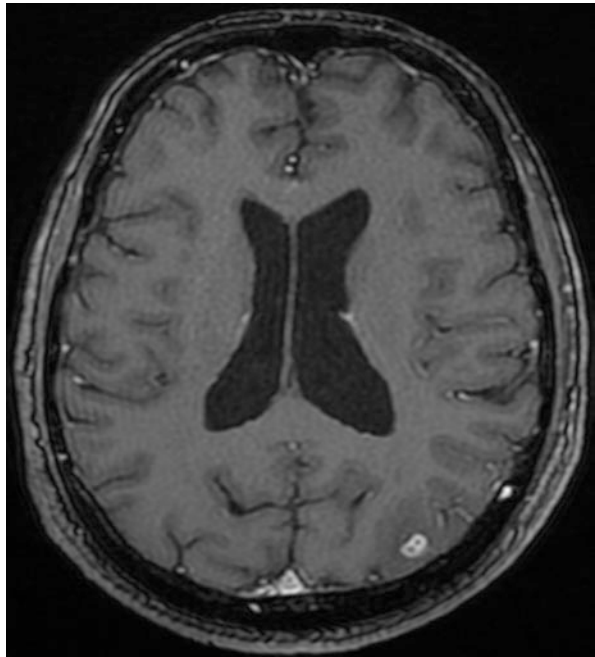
MR axial FLAIR and T2 images showing focal ring-like lesions consistent with brain abscesses or tuberculomas
